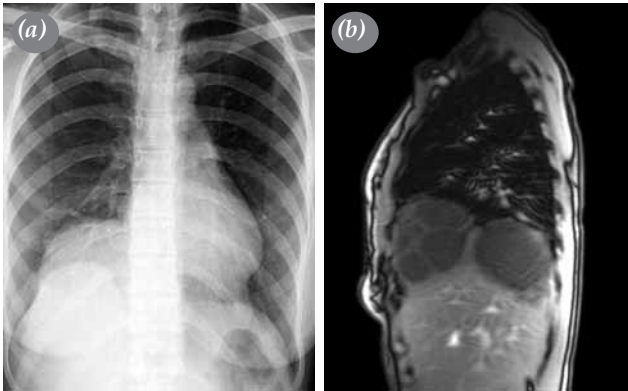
(a) Posteroanterior chest X-ray showing right diaphragmatic eventration. (b) Sagittal T₁-weighted magnetic resonance image revealing multicystic lesion in diaphragm.
